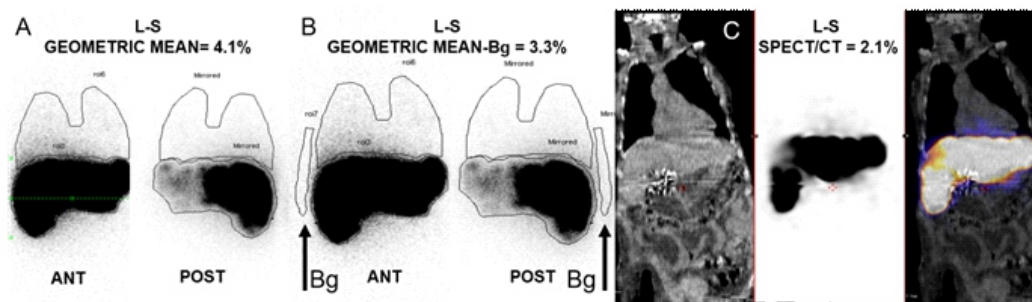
Estimation of Lung-Shunt (L-S) with planar and SPECT/CT imaging. Different values of L-S have been calculated, in the same patient, using planar imaging geometric mean (A), background corrected geometric mean (B) and SPECT/CT (C). In this case, different L-S values did not have clinical impact, however this does not apply as a general rule. Usually, planar imaging overestimates L-S.
